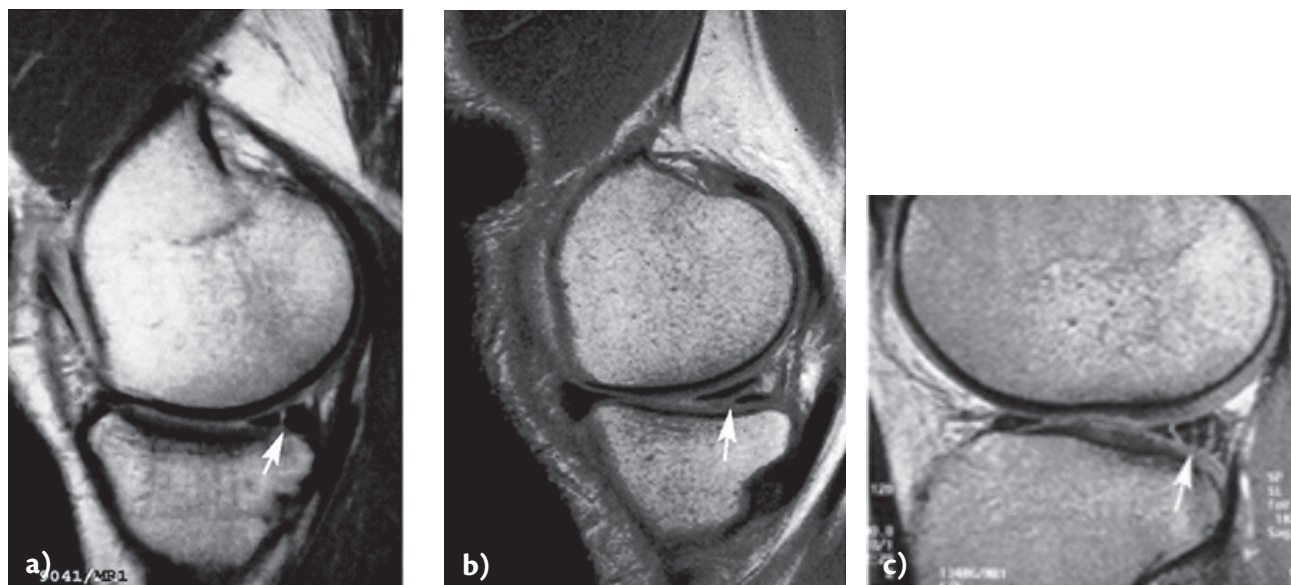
Magnetic resonance imaging can confirm the diagnosis, ruptured meniscus (see arrows). a) Vertical meniscus rupture; b) horizontal meniscus rupture; c) meniscus ruptures caused by degeneration.
